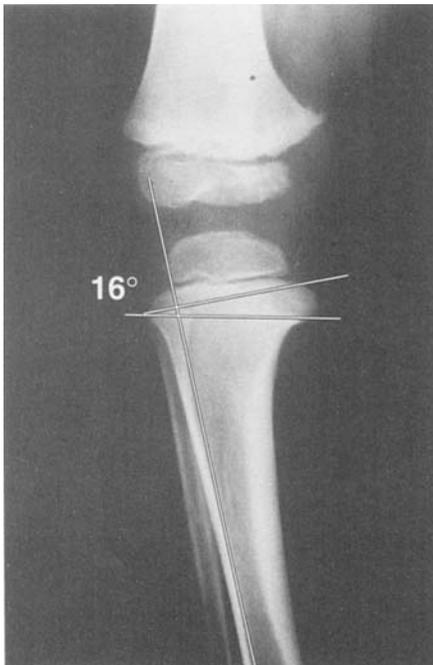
Early Blount's disease. Early Blount's disease is characterized by progressive varus angulation (bowlegs) that fails to follow the normal developmental pattern of resolution during the second and third year. Radiographic examination reveals early medial metaphyseal and epiphyseal changes. Measurement of the metaphyseal-diaphyseal (MD) angle is demonstrated. A line is drawn traversing the proximal tibial metaphysis, and another is drawn perpendicular to the axis of the lateral tibial cortex. Values greater than 11° are consistent with early Blount's disease and signify the need for close observation and, in some cases, treatment.
